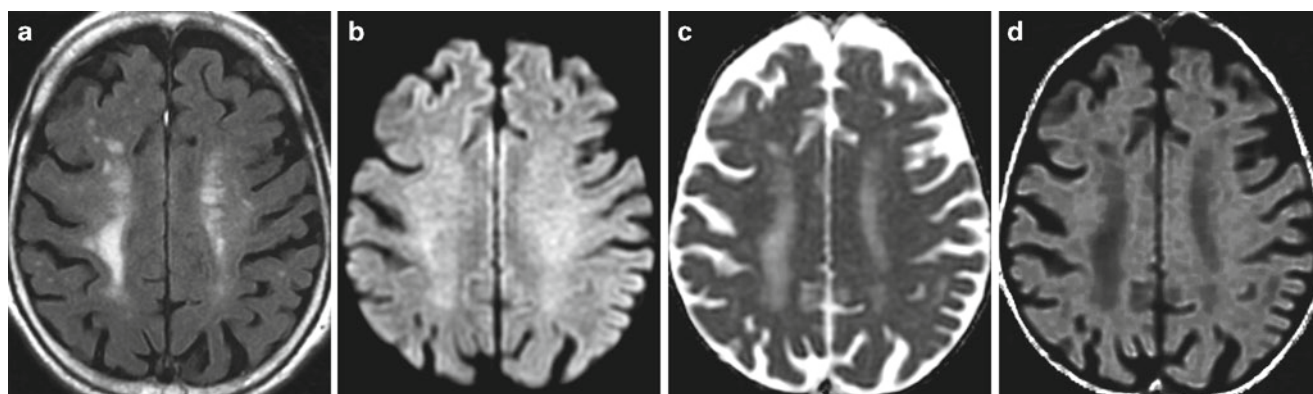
T2 shine-through. (a) Axial FLAIR image demonstrates non-specific periventricular FLAIR hyperintense lesions. (b) On DWI, mildly increased signal raises the possibility of acute ischemia.
